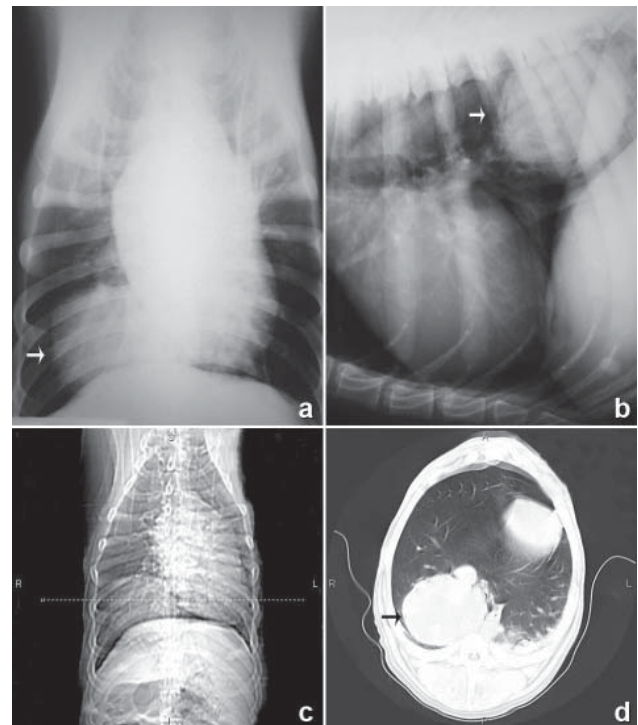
Ventrodorsal (a) and right lateral (b) radiograph views of the thorax showing a well-delimited mass localized in the right diaphragmatic pulmonary lobe. Coronal and transverse CT views at the level of the diaphragmatic pulmonary lobe (c, d). Note the round solid mass localized in the right diaphragmatic pulmonary lobe.
